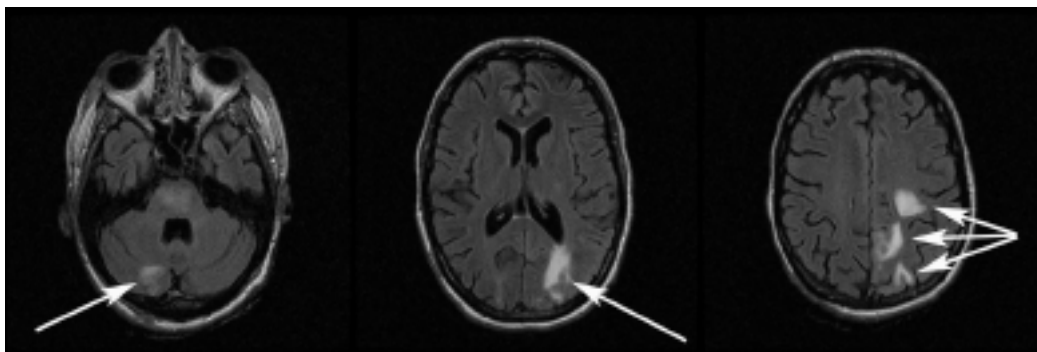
Brain MRI scans of Patient 3 show increased T2 FLAIR intensity in left parietal, occipital, and right cerebellar regions (arrows).
